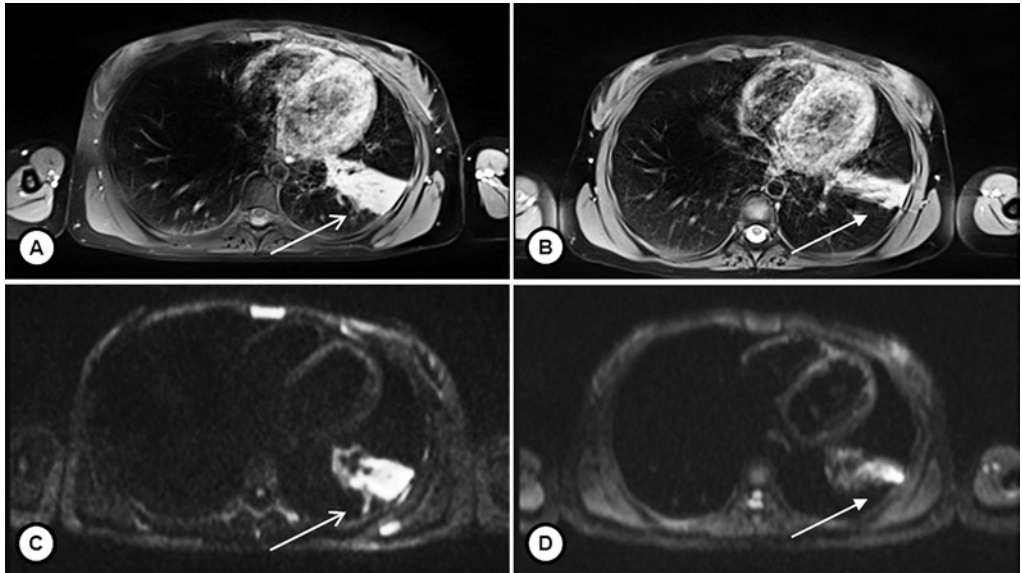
DWI changes pre (a-c) and post (b-d) RTE treatment in CF patient with respiratory tract exacerbation. Left column is imaging at baseline and right column is at follow-up. Upper row displays morphological free-breathing BLADE (Siemens) images, while lower row DW images at $b=800 \text{ mm}^2/\text{s}^2$. Note that left lower consolidation (open arrow in a) with high DWI signal (open arrow in c) became smaller after RTE treatment (close arrow in b) and DWI signal also reduced (close arrow in d).
